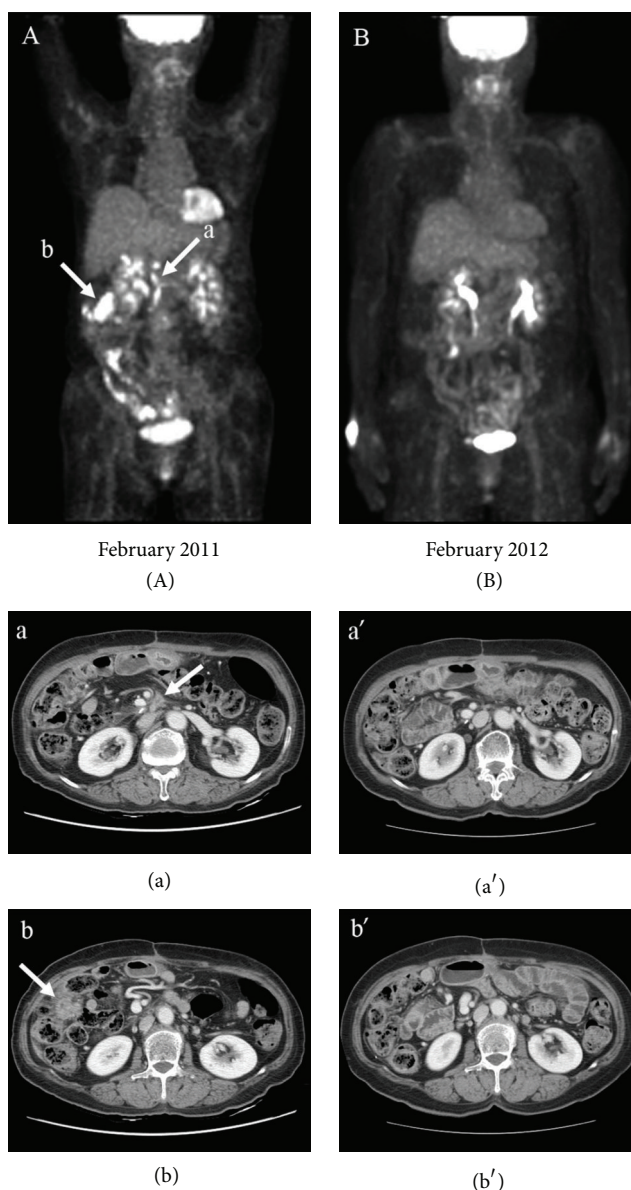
Multiple peritoneal metastases after surgery were confirmed by a PET-CT whole-body scan in February 2011 (A). The irregular speculated soft tissue mass in the proximal superior mesenteric artery lesion (20 mm; (a)) and the right side mesentery mass (32 mm; (b)) disappeared in the recent CT scans ((a') and (b')) after only aRVs treatment. All the metastases disappeared in the recent PET-CT scans in February 2012 after only aRVs treatment (B).
